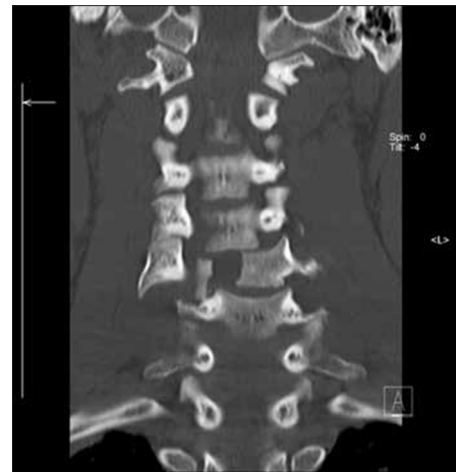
Preoperative coronal computed tomography of C5 burst fracture
